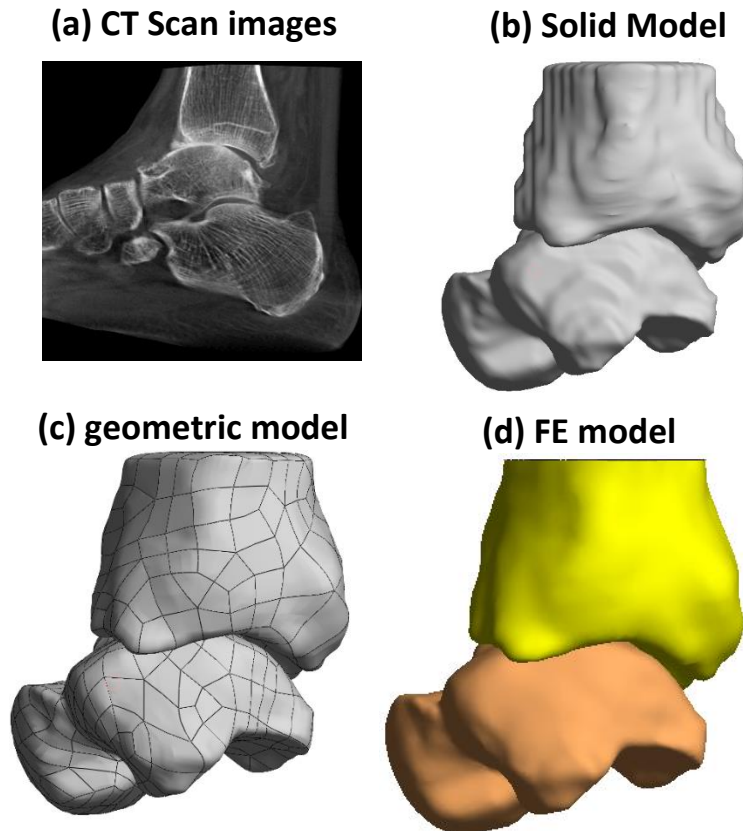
The FE model was developed based on CT scan images. As a first step, the rough solid model created in Slicer, then the geometric model developed by the Geomagic Design X software. Finally, the smooth FE model was created in Hypermesh.
